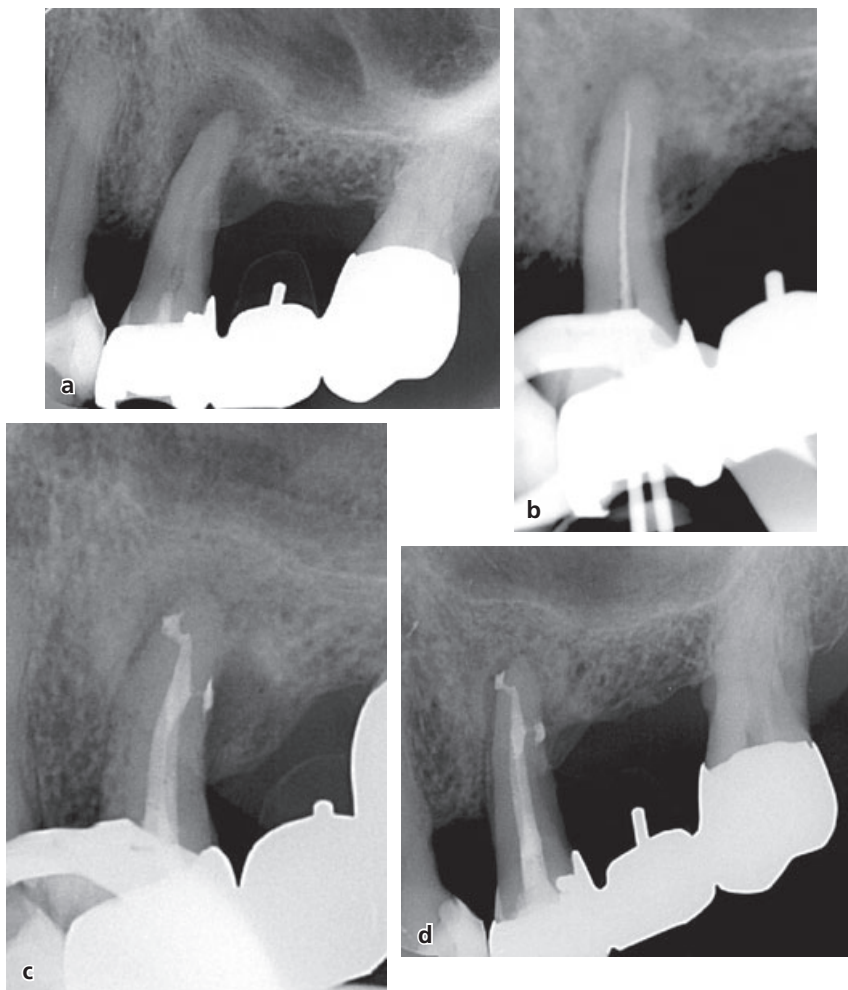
Series of radiographs showing endodontic treatment of an upper premolar included as an abutment in a three-unit bridge. The patient, a 78-year-old male, had been treated and maintained for periodontal disease. (a) There are bone lesions both at the apical and at the distal aspect of the tooth. Following endodontic treatment of the necrotic pulp (b) and root filling (c), an accessory canal communicating with the lateral lesion became evident. (d) The 6-month recall radiograph shows substantial reduction of both bone lesions. Case kindly provided by Dr. Peter Jonasson.
